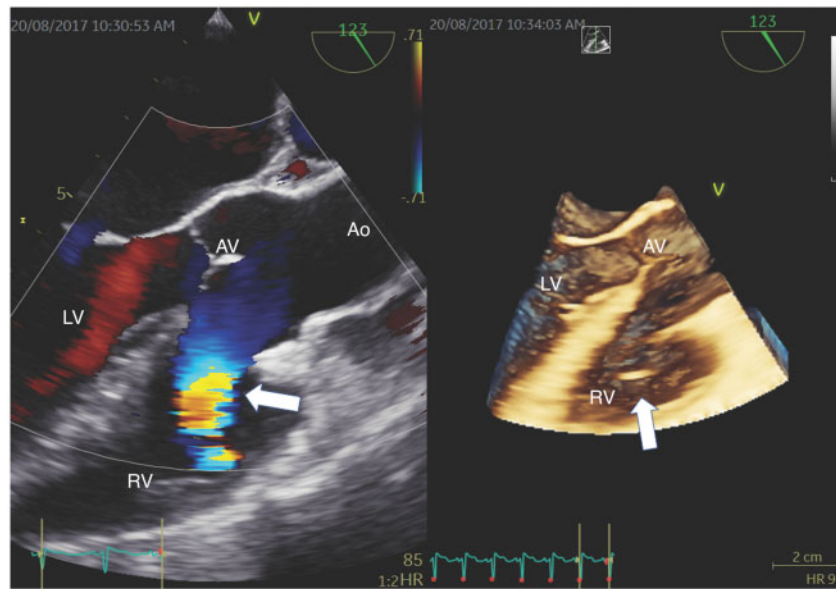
Left image showed a transesophageal echocardiography long-axis view (120°) showing the ruptured sinus of Valsalva aneurysm with a left-to-right shunt towards the right ventricle. The right image shows a three-dimensional view of the ruptured sinus. Ao, •••; AV, •••; LV, left ventricle; RV, right ventricle.
